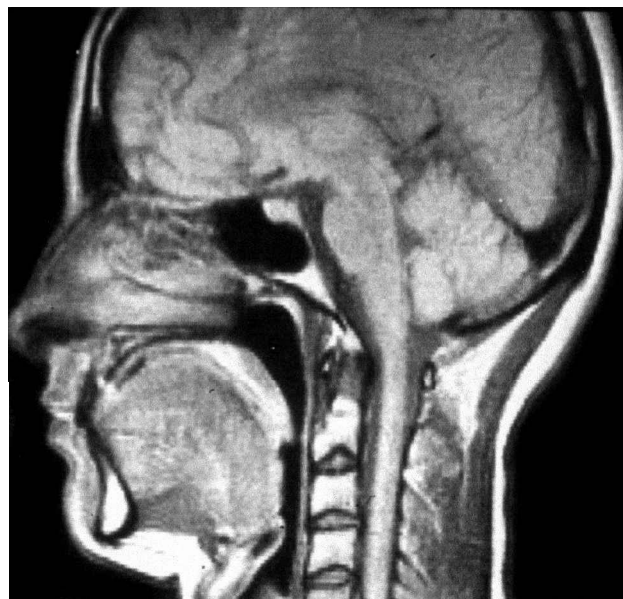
MRI of the brain and cervical spine in a patient with a normal position of the brainstem and cerebellum.
